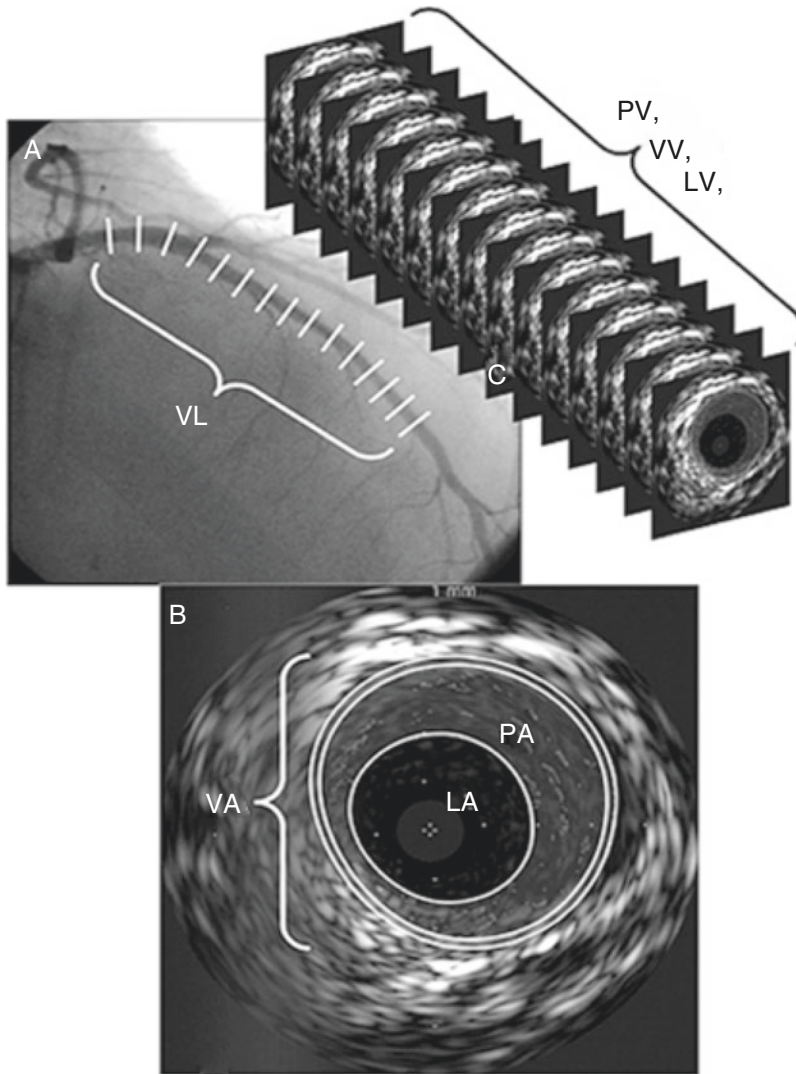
Methods for conducting three-dimensional intravascular ultrasound (IVUS) examinations and definitions of IVUS measurements (From Topilsky et al. 2012). IVUS is performed during coronary angiography with mechanical pullback (0.5 mm/s) usually from the mid-to-distal left anterior descending coronary artery to the left
